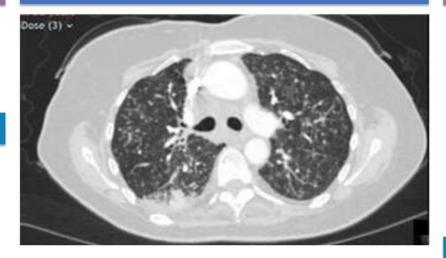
CT Chest comparison over a 2-week period showing marked worsening of lung findings
